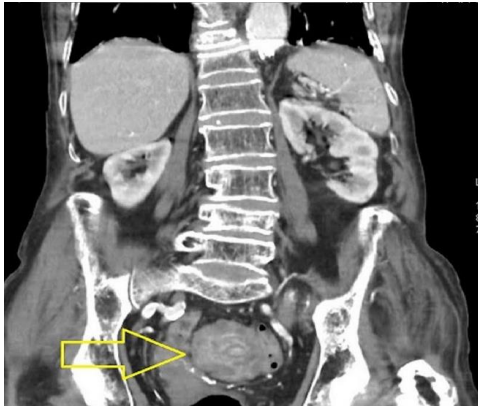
abdominopelvic CT scan with injection of contrast product, on coronal reconstruction, showing a hypogastric tissue mass
